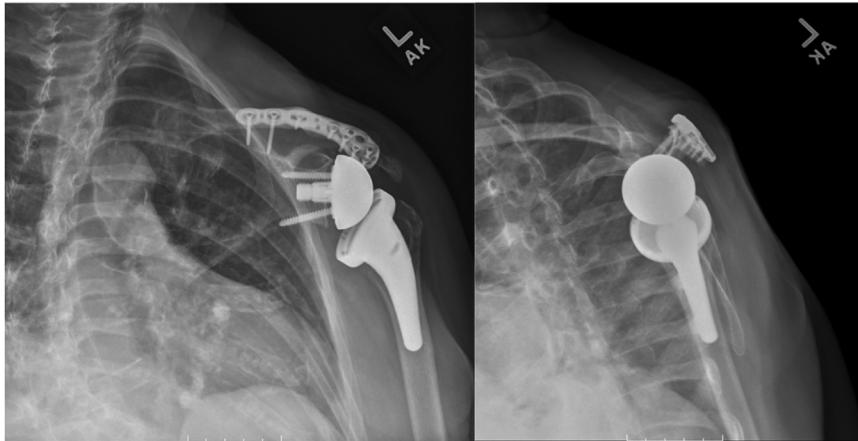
Radiographs of the right shoulder taken 1 year postoperatively.
